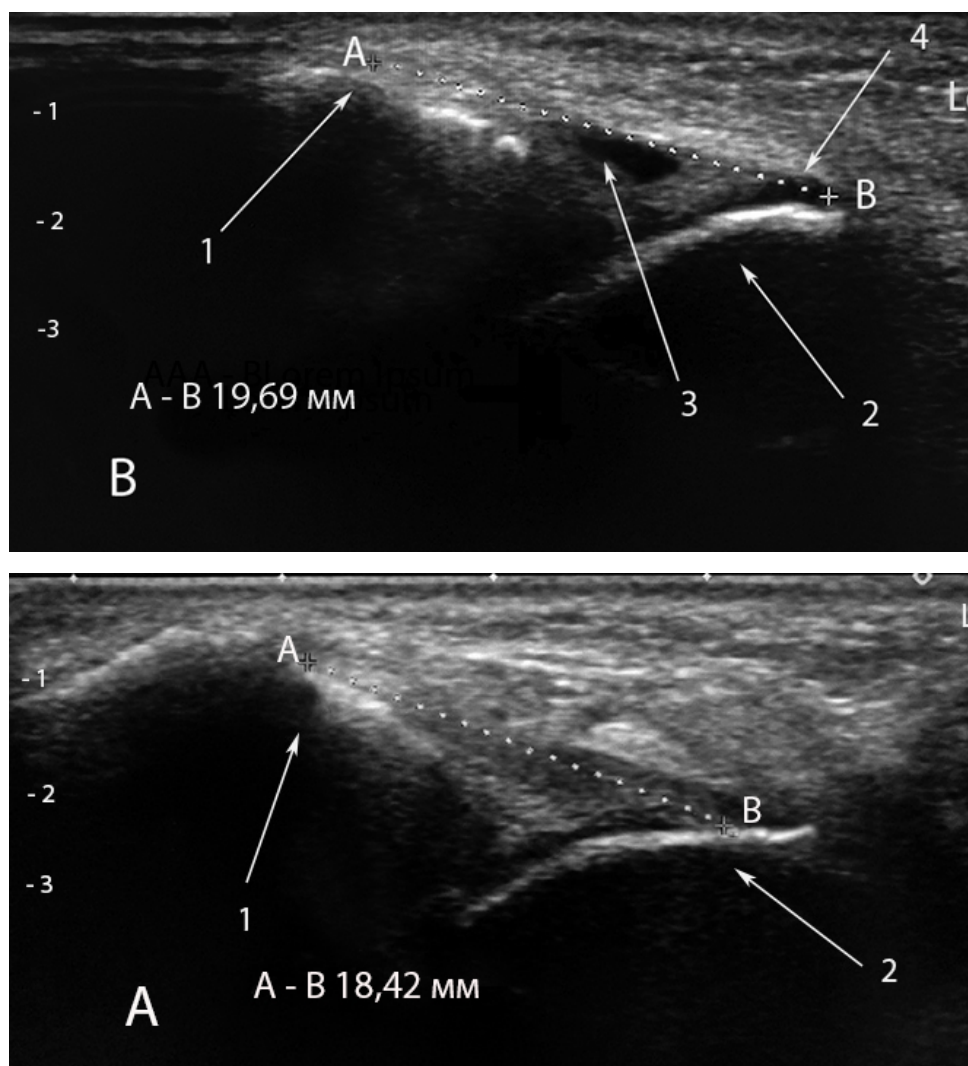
Anterior talo-fibular ligament of the experimental group patient with chronic ankle-foot joint instability during sonography. A. Dimensions of the anterior talo-fibular ligament in a neutral position in a patient of the experimental group with chronic ankle-foot joint instability (A-B measurement points of the anterior talo-fibular ligament. 1 - fibula; 2 - talus). B. Dimensions of the anterior talo-fibular ligament at maximum inversion loading in a patient of the experimental group with chronic instability of the ankle-foot joint (A-B measurement points of the anterior talo-fibular ligament. 1 - fibula; 2 - talus; 3 - free fluid in the joint cavity; 4 - place of detachment of the anterior talo-fibular ligament from the talus)
